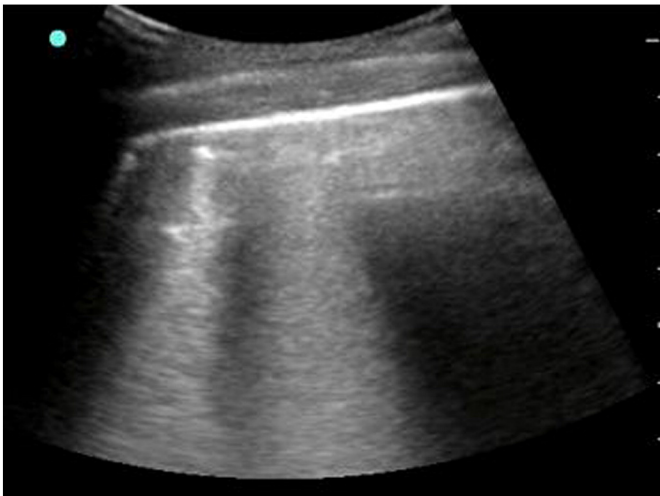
Typical lung ultrasound of interstitial syndrome.
